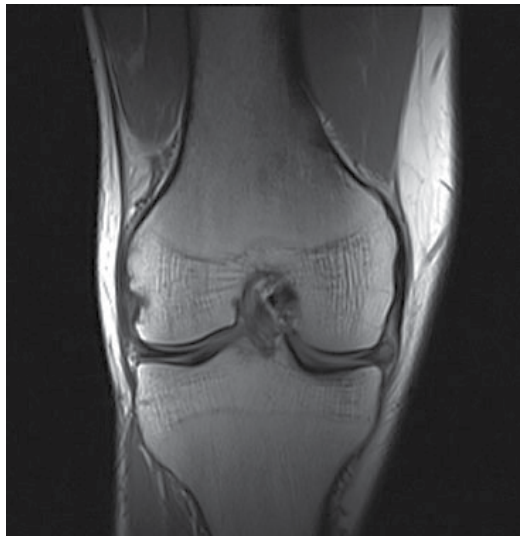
An MRI coronal view. Note the difference between thickness of the body of lateral and medial menisci.
